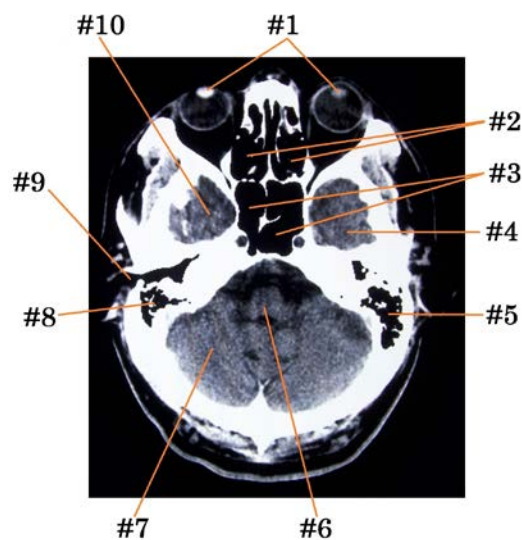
CT axial cross-sectional image of the cranium/brain.
